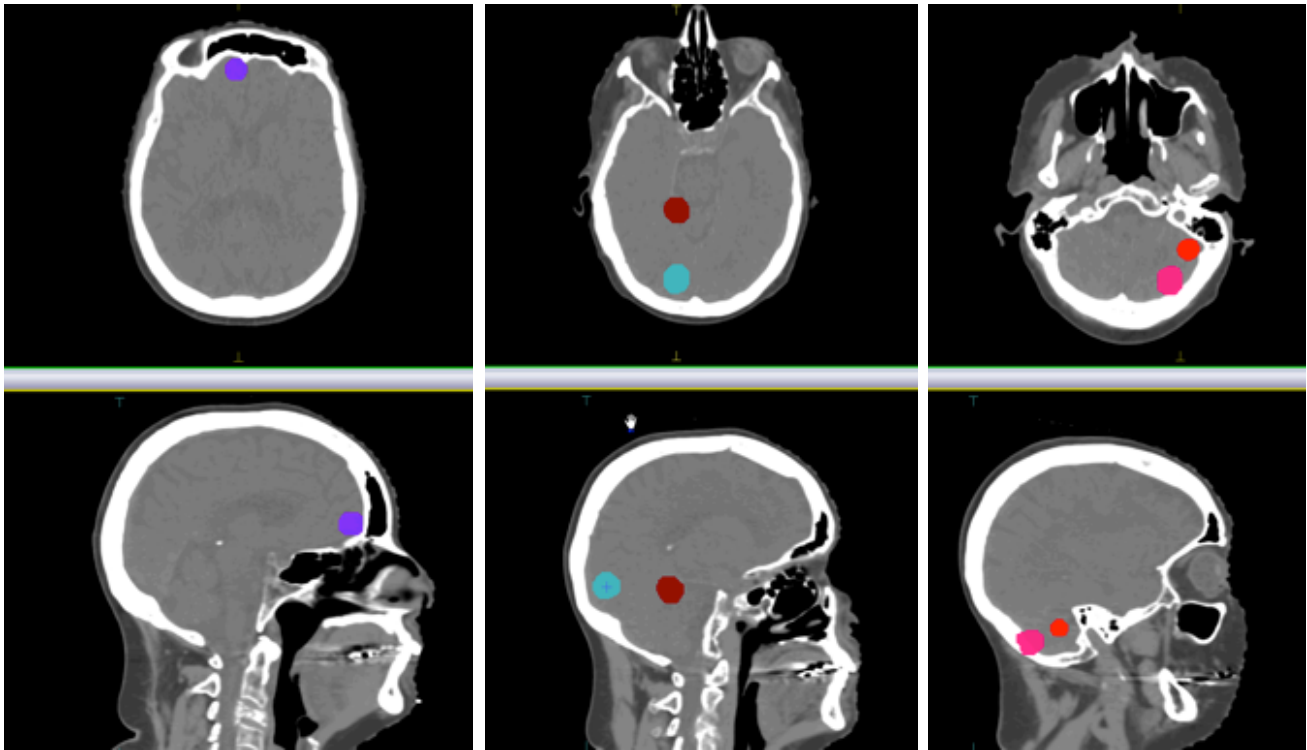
Planning CT scan. Transverse and sagittal slices of 5 brain metastases.
